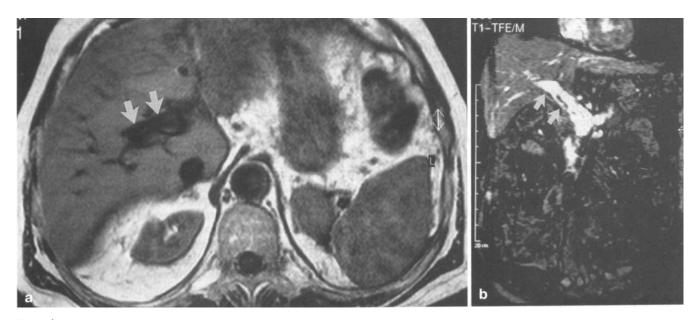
Successful recanalization of portal vein thrombosis after a ten day course of low dose rt-PA: T1-weighted axial images (a) and coronal magnetic resonance angiography; (b) of the abdomen demonstrate recanalization of the portal vein with regular flow patterns (arrows)
